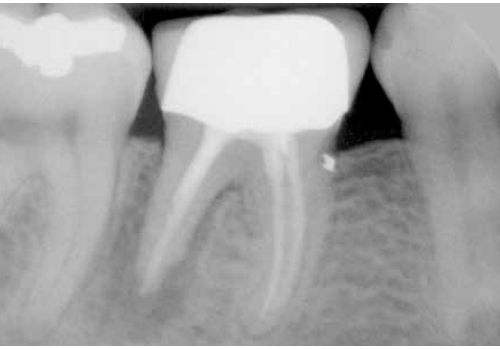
The x-ray shows a tooth not worth preserving in regio 46.
